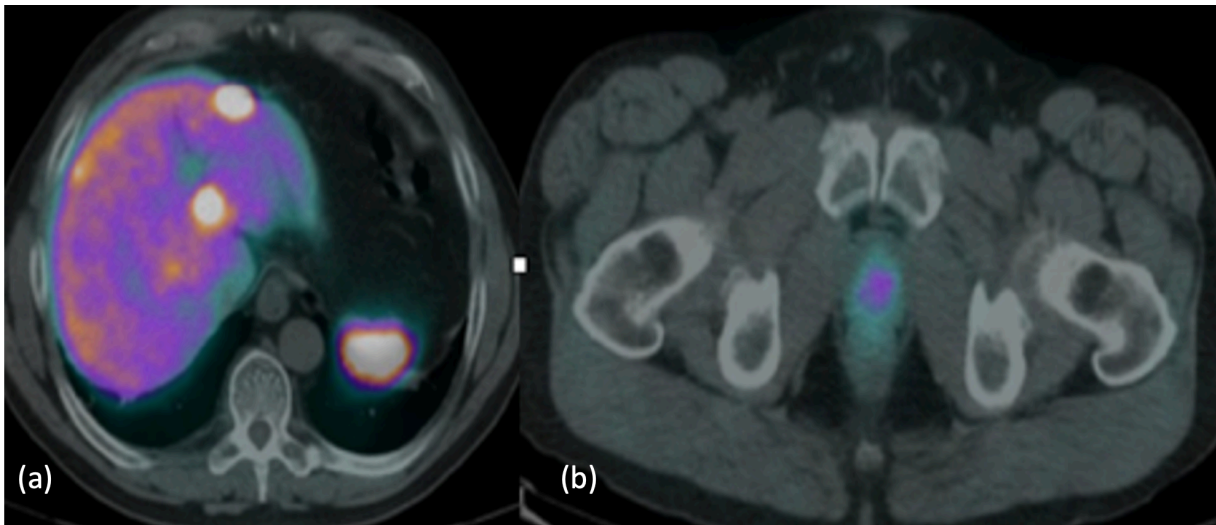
(a) ^{68}Ga Gallium Octreotate axial fused PET/CT (upper abdomen and pelvis) image in a patient with metastatic pancreatic neuroendocrine tumour. There are multiple tracer avid liver metastases. (b) In addition there is focal intense Somatostatin receptor expression in the prostate gland.
